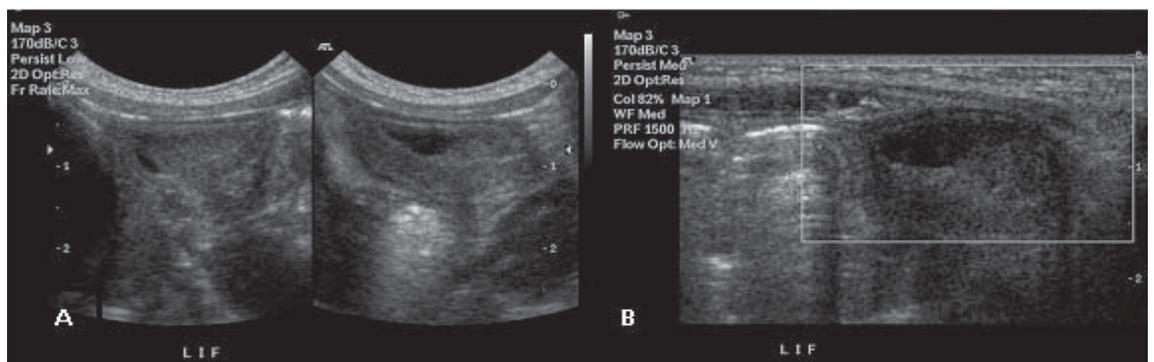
Patient 3: Heterogeneous mass with 'fish-net appearance'. No internal vascularity on colour Doppler sonography.
